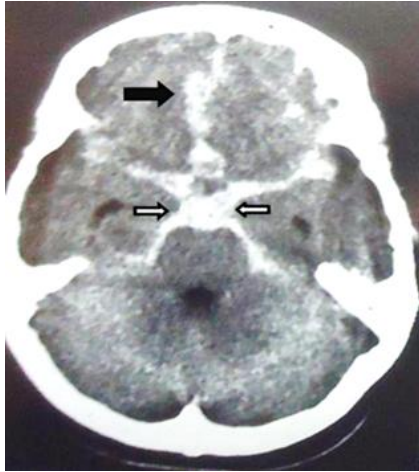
CT image of diffuse SAH: (➤) blood in the hemispheric cistern; (⇨) blood in the suprasellar cisterns
